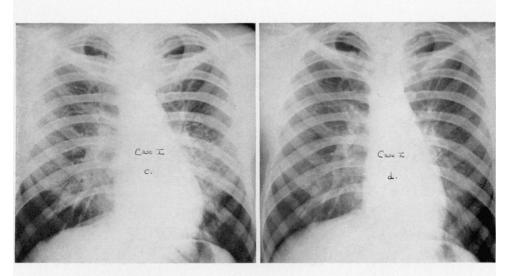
(Case I). Series of x-rays showing the development and subsidence of the lung shadows in one patient.
